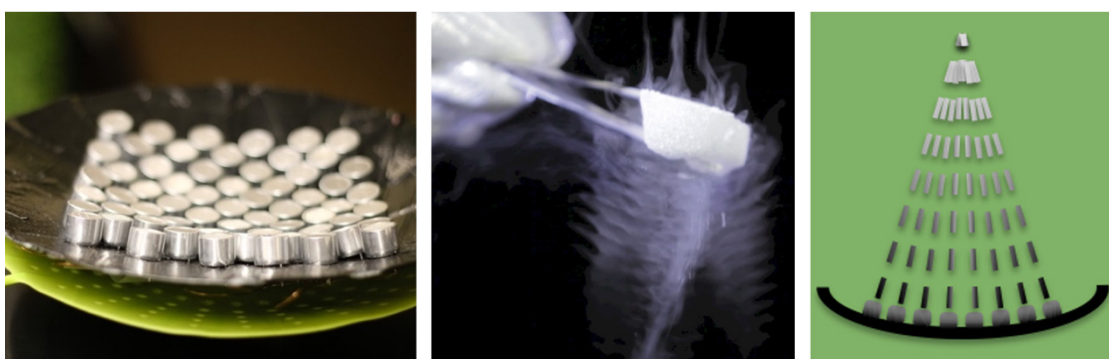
From left to right- ultrasonic transducer array arranged in a parabolic dish, mid-air ultrasound waves become visible with a bit of dry ice, a representation of the ultrasonic transducers aligned to create a strong mid-air force field in the focal point.
